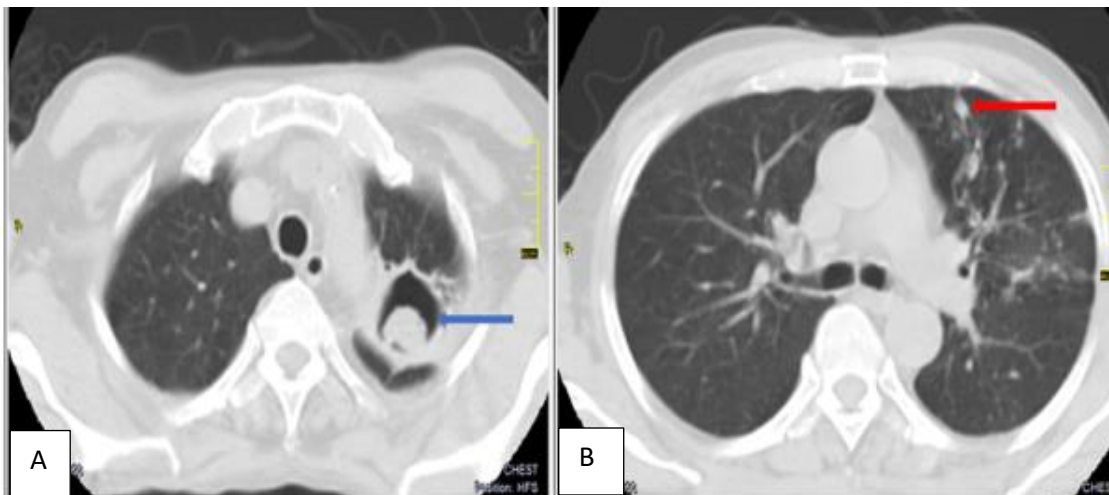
Axial contrast CT scans, axial lung window of chest of second CPA patient diagnosed at T2 showing A) a soft tissue mass within a left apical lung cavity (blue arrow) with a characteristic crescent of air around it, the monad sign, indicative of an aspergilloma. B). Nodular opacities (red arrow) and non pericavitary fibrotic changes in the left upper lobe.
